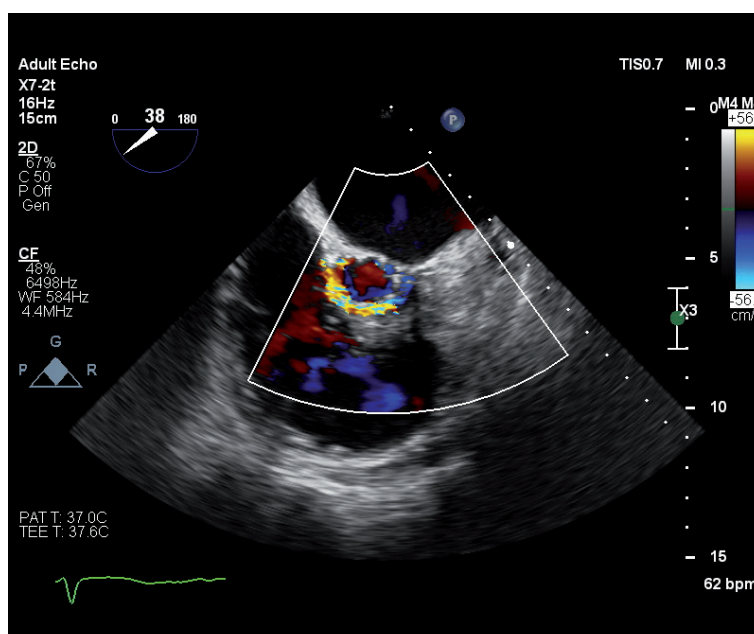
Transthoracic echocardiography showing the severe paravalvular aortic leak at the site of the right coronary and non-coronary cusps
